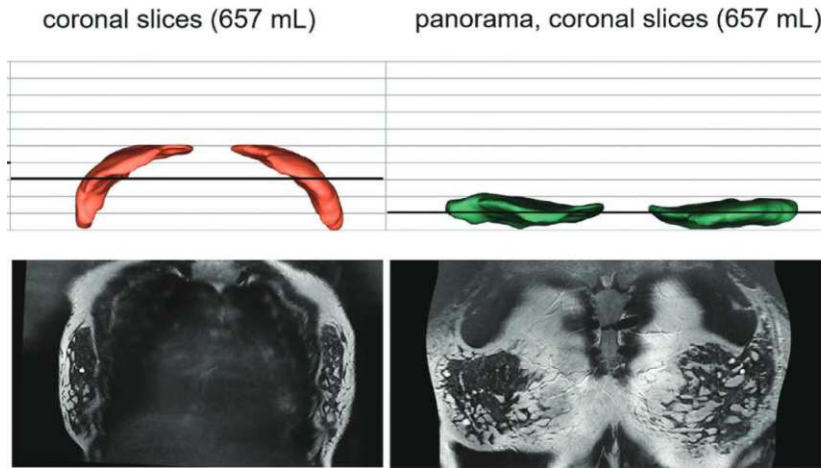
Panoramic breast MRI (right) compared to the standard coronal view (left), demonstrating a reduction in the number of slices required for interpretation (adapted from [43]).
